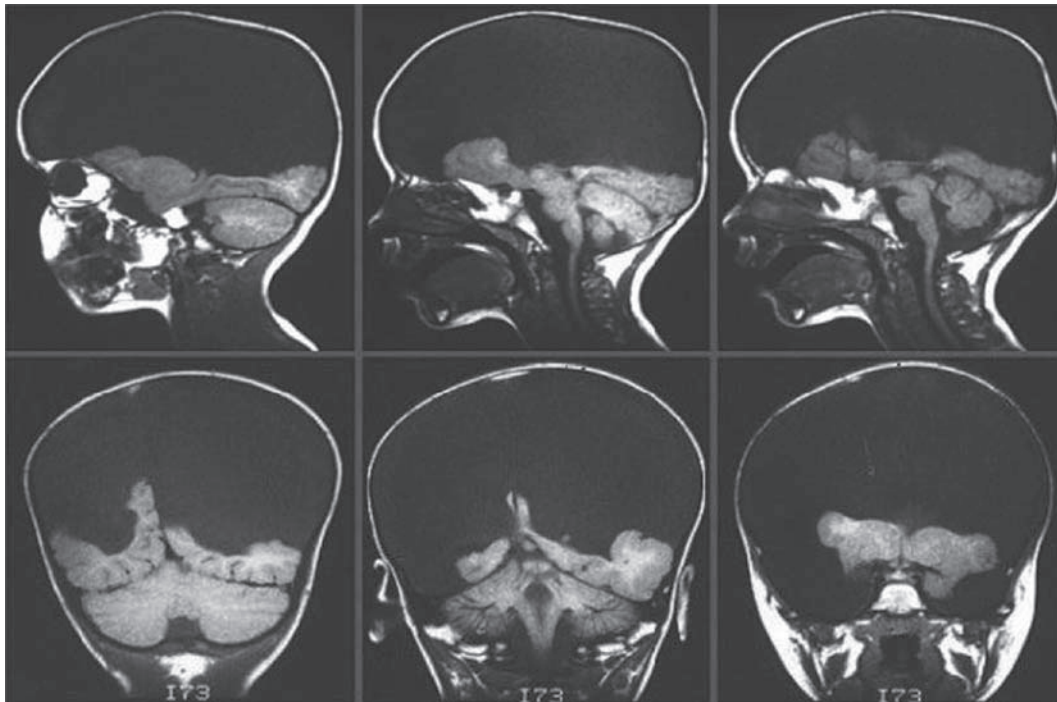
Missing cortex in a hydranencephalic child. An MRI scan of a baby with hydranencephaly. The dark upper half of the cranium in the X-ray photos is filled only with fluid. The cerebellum and brainstem appear to be intact. The basal brain is responsible for basic sleep and arousal, and the child may seem to have normal sleep-waking cycles for some time after birth. The surprise is that babies with hydranencephaly may behave somewhat normally, and only reveal visible deficits over a period of months. The cause of this disorder is not currently understood. *Source:* Merker, 2007.
